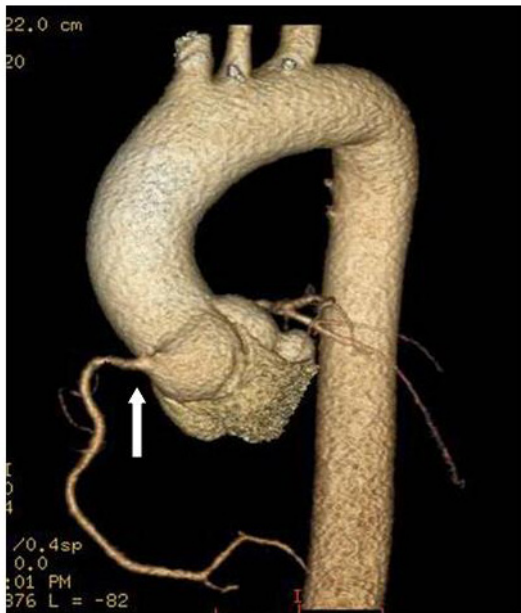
Left, A reconstructed computed tomogram depicting the anomalous high origin of the left main coronary artery (arrow) from the left coronary sinus. Right, Computed tomographic angiography image showing the high origin of the left main coronary artery being pushed upward (arrow) by the left sinus of Valsalva aneurysm (\*).
